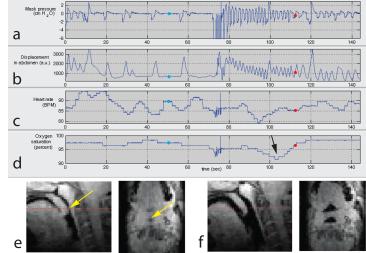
Sample physiological signals (a-d) and captured 3D-MRI frames (e,f), with only mid-sagittal and axial images shown, during central sleep apnea (light blue dots) (e) and tidal breathing (red dots) (f). Oxygen saturation nadir (arrow in (d)) indicates an apnea. The arrows in (e) indicate retropalatal airway obstruction during central apnea.
